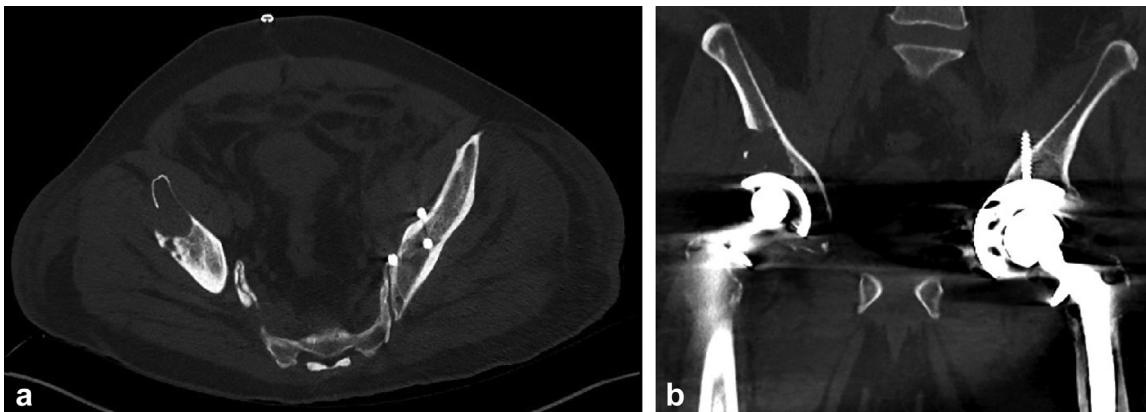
Postoperative CT of pelvis demonstrating intrapelvic placement of iliac screws on axial (a) and coronal slices (b).
